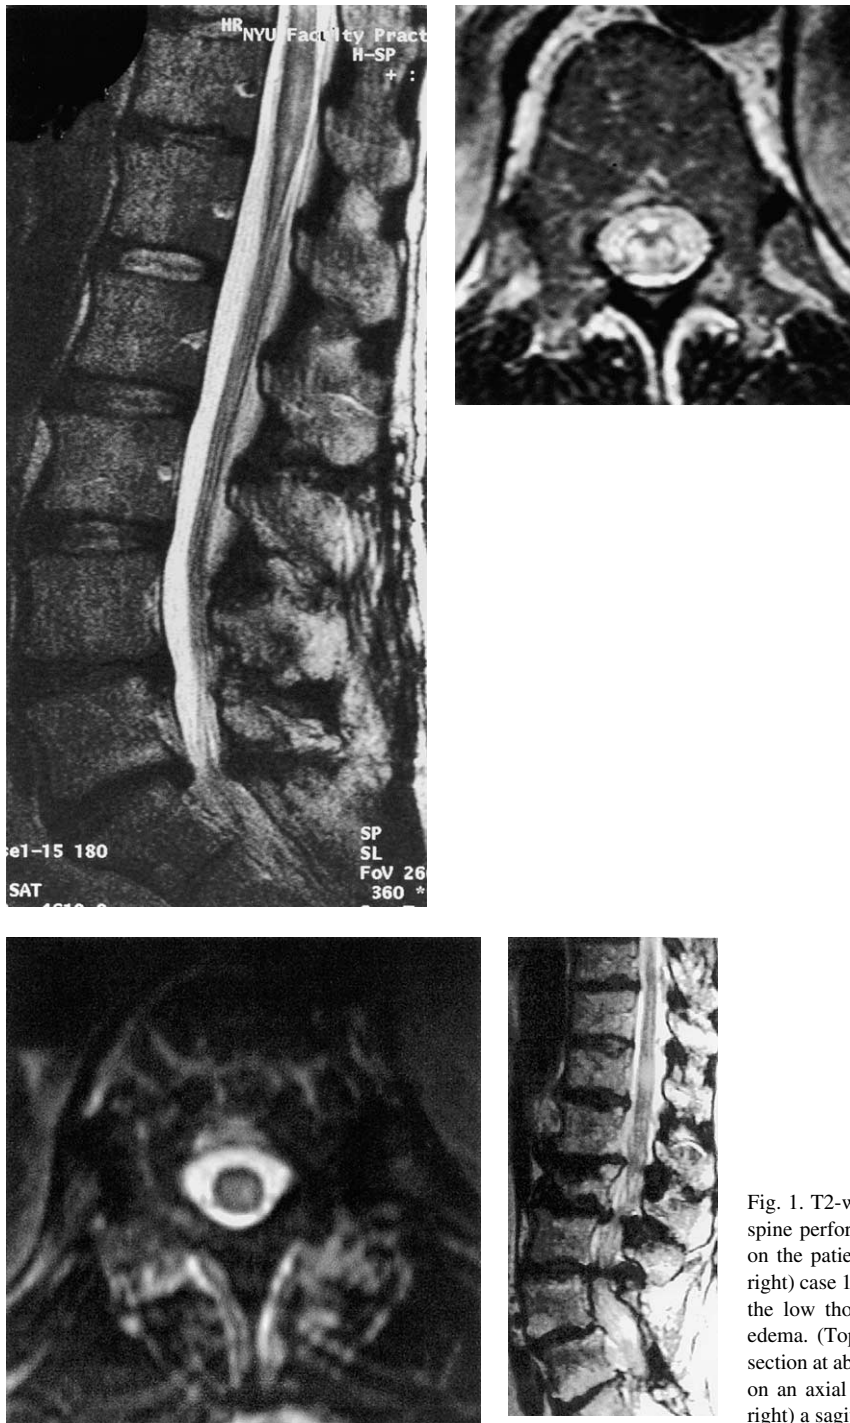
T2-weighted magnetic resonance image of the thoracolumbar spine performed within 48 hours of the onset of neurological deficit on the patient from (top left and right) case 3 and (bottom left and right) case 1. (Top left) A sagittal section reveals marked expansion of the low thoracic spinal cord with increased signal consistent with edema. (Top right) These findings are also appreciated on an axial section at about the T12 level. (Bottom left) Similar findings are noted on an axial slice at about T12 in the patient in case 1 and (bottom right) a sagittal slice taken from the patient in case 2.
